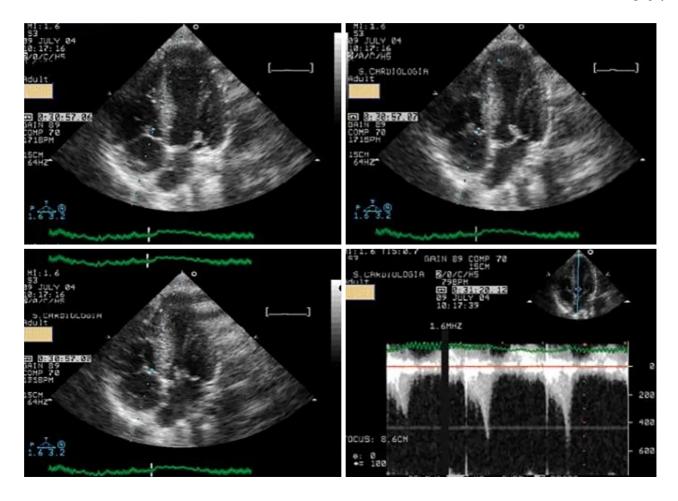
Systolic anterior movement of the mitral valve and significant intraventricular gradient detected at peak exercise. Citation: Cotrim C, João I, Fazendas P, Almeida AR, Lopes L, Stuart B, Cruz I, Caldeira D, Loureiro MJ, Morgado G, Pereira H. Clinical applications of exercise stress echocardiography in the treadmill with upright evaluation during and after exercise. Cardiovasc Ultrasound 2013; 11: 26 [PMID: 23875614 DOI: 10.1186/1476-7120-11-26] Copyright © The Author (s) 2013. Published by BMC part of Springer Nature.
